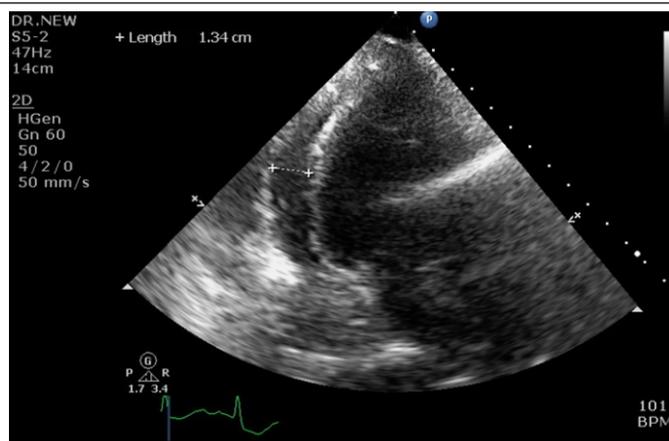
Echocardiogram showing moderate pericardial effusion with impending cardiac tamponade.
